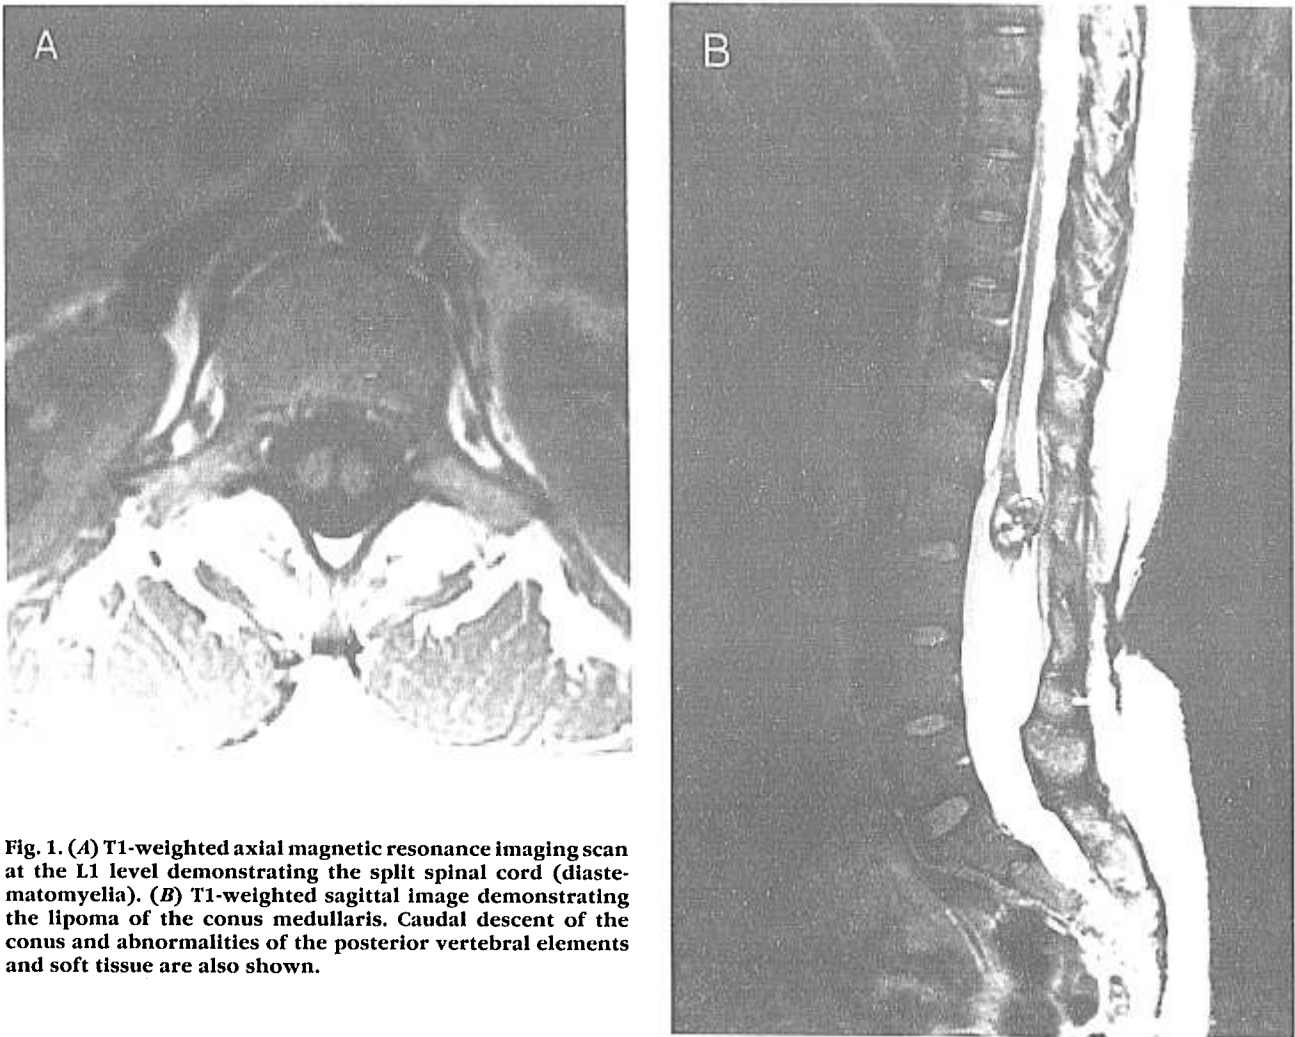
(A) T1-weighted axial magnetic resonance imaging scan at the L1 level demonstrating the split spinal cord (diastematomyelia). (B) T1-weighted sagittal image demonstrating the lipoma of the conus medullaris. Caudal descent of the conus and abnormalities of the posterior vertebral elements and soft tissue are also shown.
